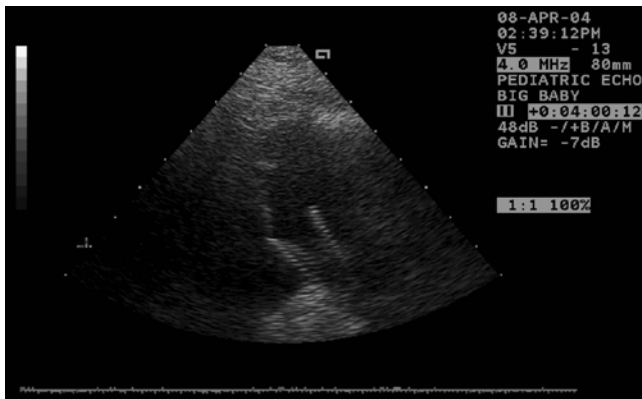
On the parasternal short axis view, no pulmonary valve opening is shown.
